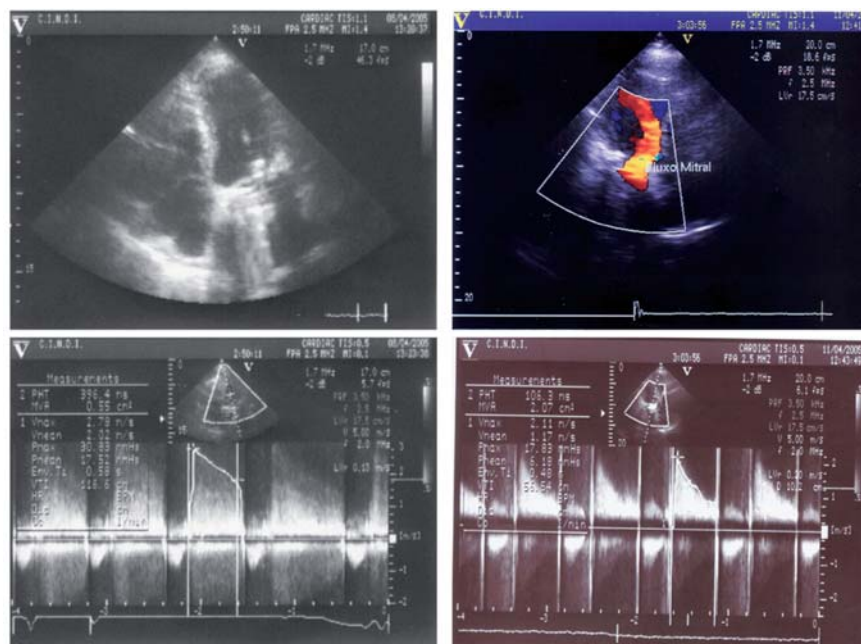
Transesophageal echocardiogram. Left, prior to thrombolytic therapy, and right, three days after treatment.
